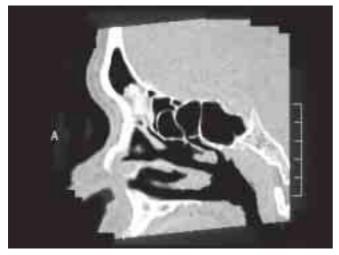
Sagittal view of reconstruction CT scan showing right frontal sinus osteoma extending postero-inferiorly.
